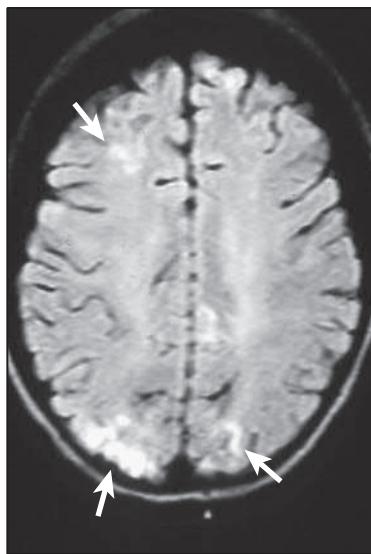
Magnetic resonance image of the brain in sickle cell disease showing multiple cerebral infarcts (arrows).
